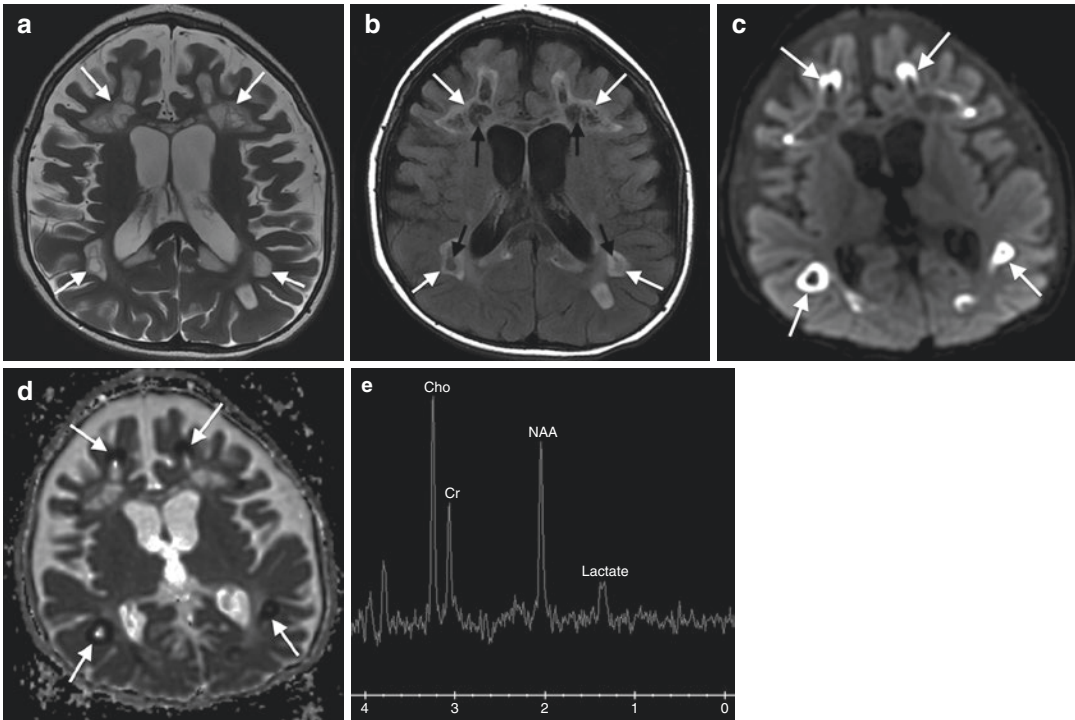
22-month-old male with a mitochondrial disorder (cytochrome C oxidase deficiency). Axial T2WI (TR/TE ms, 3200/101) (a), T2 FLAIR (TR/TE/IT ms, 10,000/148/2250) (b), DWI (TR/TE ms, 10,000/82) (c), and ADC (TR/TE ms, 10,000/82) (d) through the lateral ventricular level. Extensive multifocal and coalescent subcortical, deep, paraventricular cerebral white matter and corpus callosum lesions are present.
